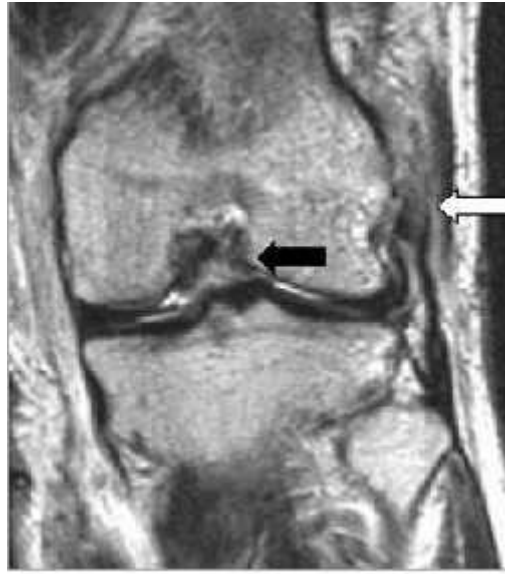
The lateral collateral ligament is lax and its fibers are interrupted at its origin (white arrow) on this coronal fast spin-echo T2-weighted image. Note the associated anterior cruciate tear (black arrow)⁽⁵³⁾.
